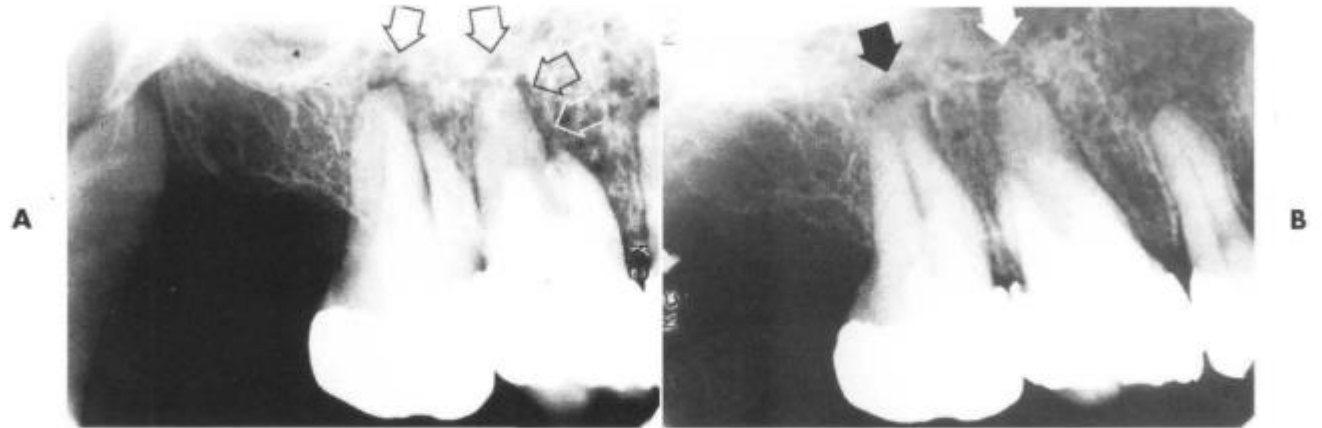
Periapical radiographs. Arrows indicate bony destruction and periapical radiolucencies at the apices of the premolar and molar teeth, all caused by squamous cell carcinoma of the maxillary sinus. Note the bandlike widening of periodontal ligament spaces in the periapices. (Courtesy R. Copeland, Libertyville, Ill.)
